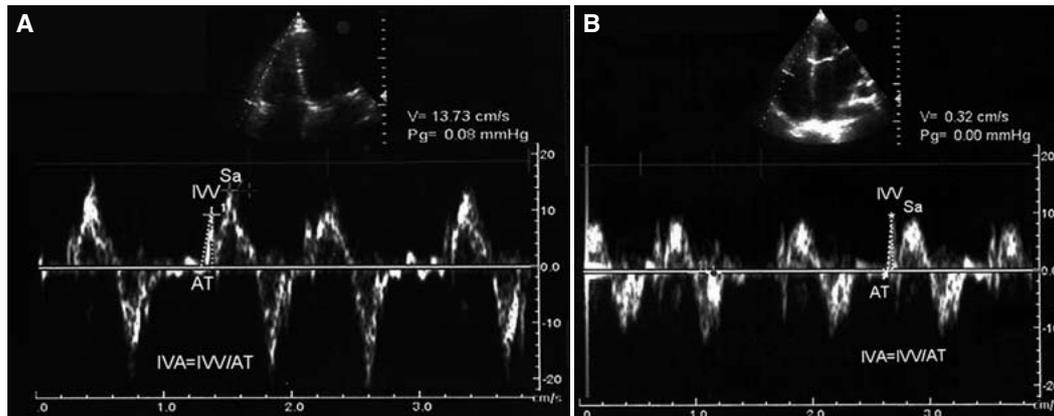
Tissue Doppler-derived myocardial systolic velocities obtained from the tricuspid lateral annulus. IVV, Sa and IVA measurements of two patients (A) with and (B) without mitral stenosis. IVV: Peak myocardial velocity during isovolumic contraction; Sa: Peak velocity during ejection period of systole; AT: Acceleration time; IVA: Myocardial acceleration during isovolumic contraction.
